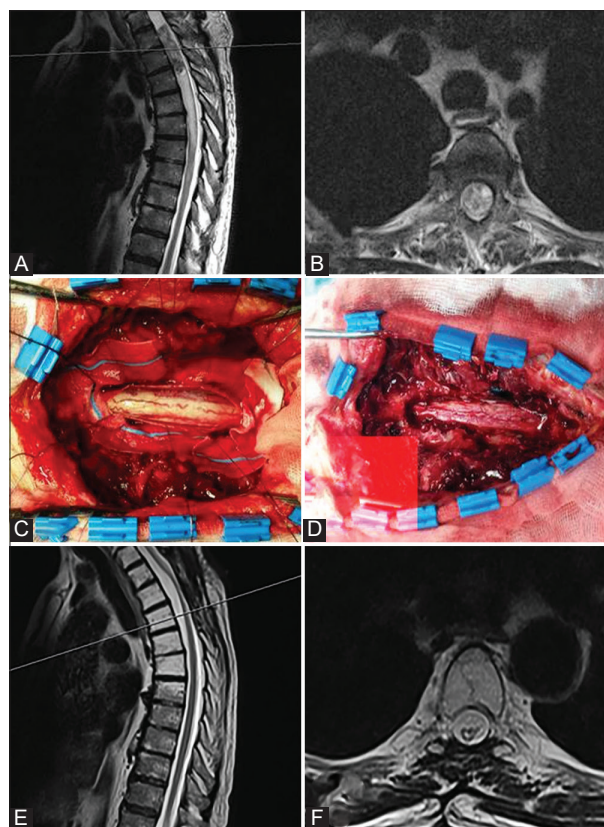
Spinal endymoma resection: (A) Pre-operative lateral magnetic resonance imaging profile showing the neoplastic formation at the level of C2/C3. (B) Magnetic resonance imaging findings revealing tumor heterogeneity. (C) Intraoperative image before the removal of the endymoma. (D) Post-operative image displaying the spinal cord after complete tumor resection. (E) and (F) 6-month post-operative magnetic resonance imaging verification of the tumor absence.
